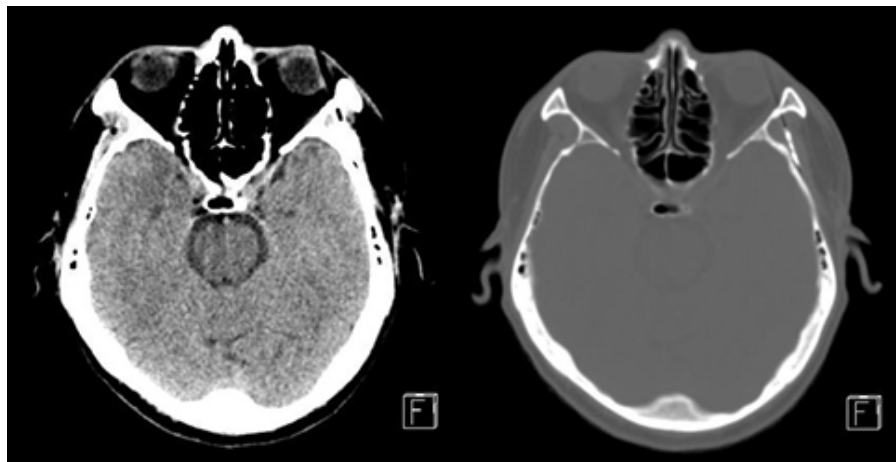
This is a trasverse brain CT image taken one year after surgery. Temporal bone fusion can be confirmed.
